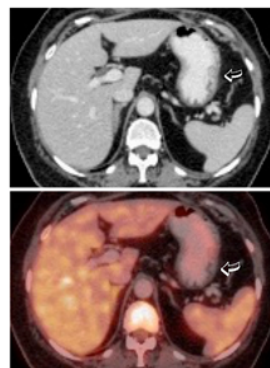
Post Chemotherapy fused PET-CT images shows significant regression in size as well as FDG avidity of the nodular soft tissue after chemotherapy.
